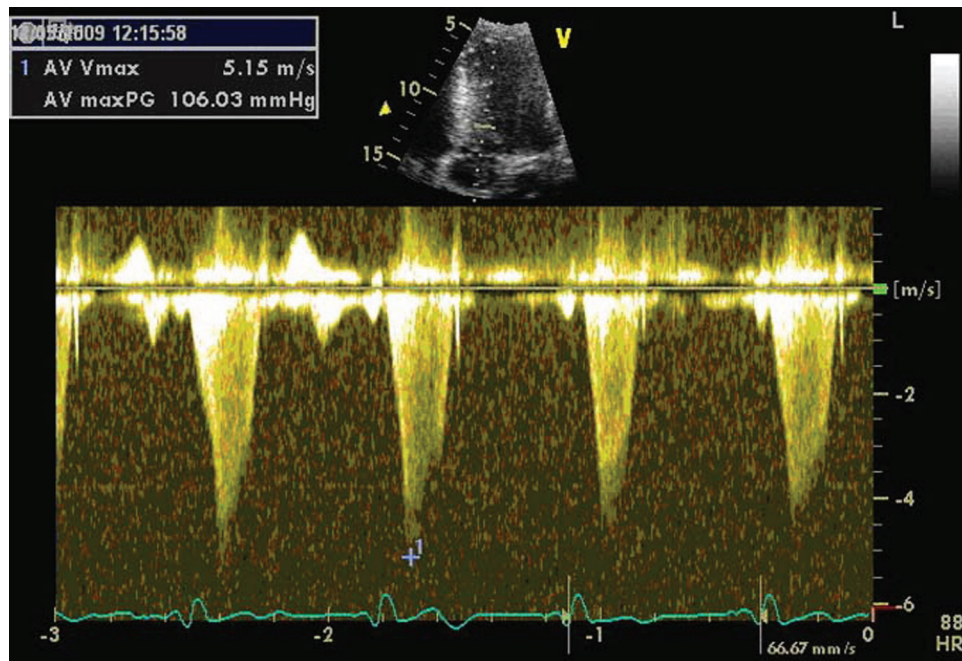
Continuous wave Doppler through the left ventricular outflow tract showing a severe gradient with classical dagger shaped contour.
